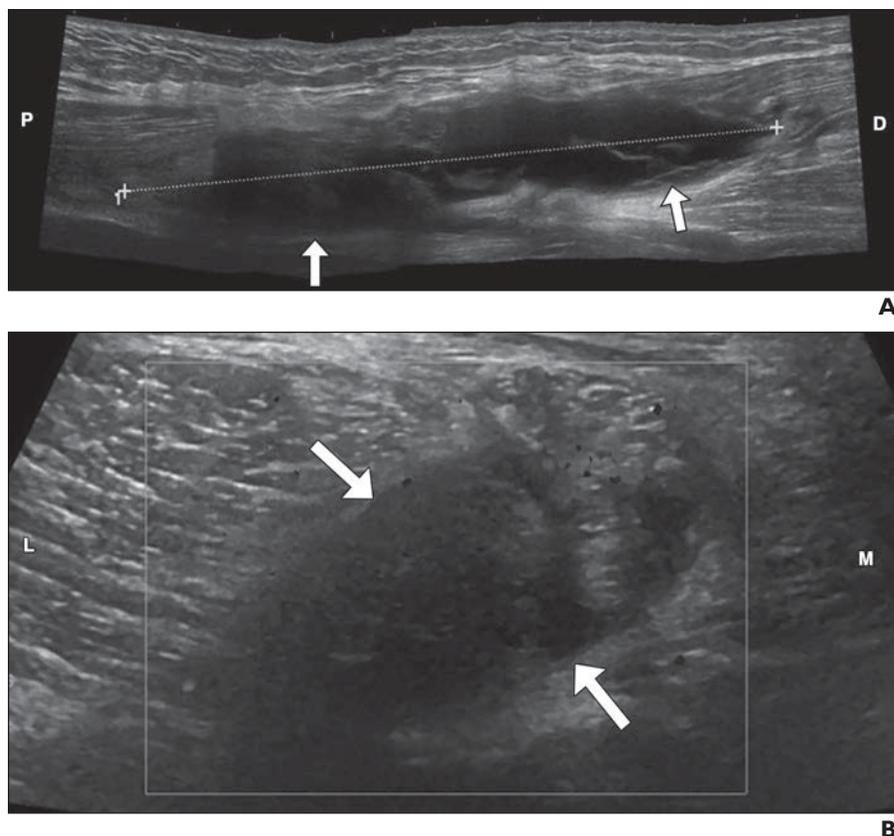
53-year-old man with semimembranosus tear. A and B, Longitudinal extended FOV (A) and transverse (B) sonograms show complete tear of proximal semimembranosus muscle and tendon retraction filled with hematoma (arrows). Calipers and dotted line (A) denote fluid-hematoma at site of tendon tear. D = distal, L = lateral, M = medial, P = proximal. C, Corresponding sagittal MRI confirms semimembranosus tear with tendon retraction and hematoma (arrows). A = anterior, P = posterior.
